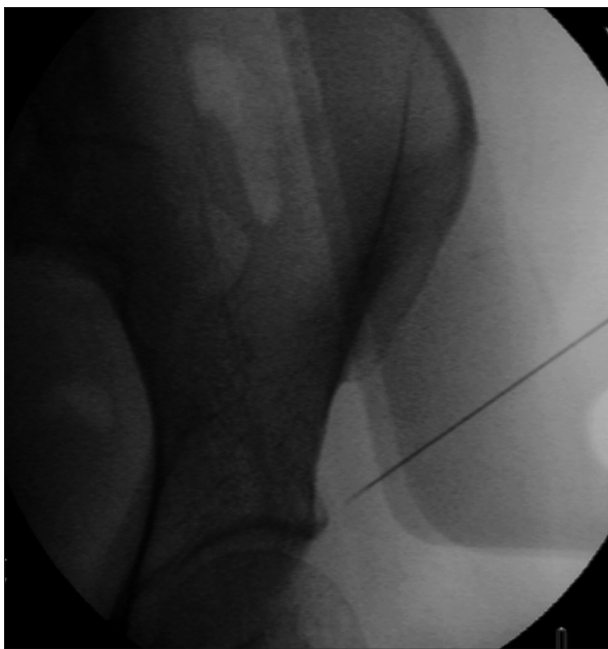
An anteroposterior radiograph showing the entry point of the radiofrequency needle inserted to block the lateral femoral cutaneous nerve below the anterior superior iliac spine under the inguinal ligament.
